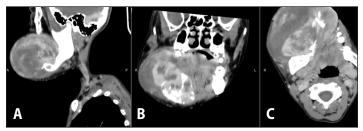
CT scan, soft tissue window, multiplanar view with contrast showing the lytic changes in the right mandible. A. lateral view; B. coronal view; C. axial view
